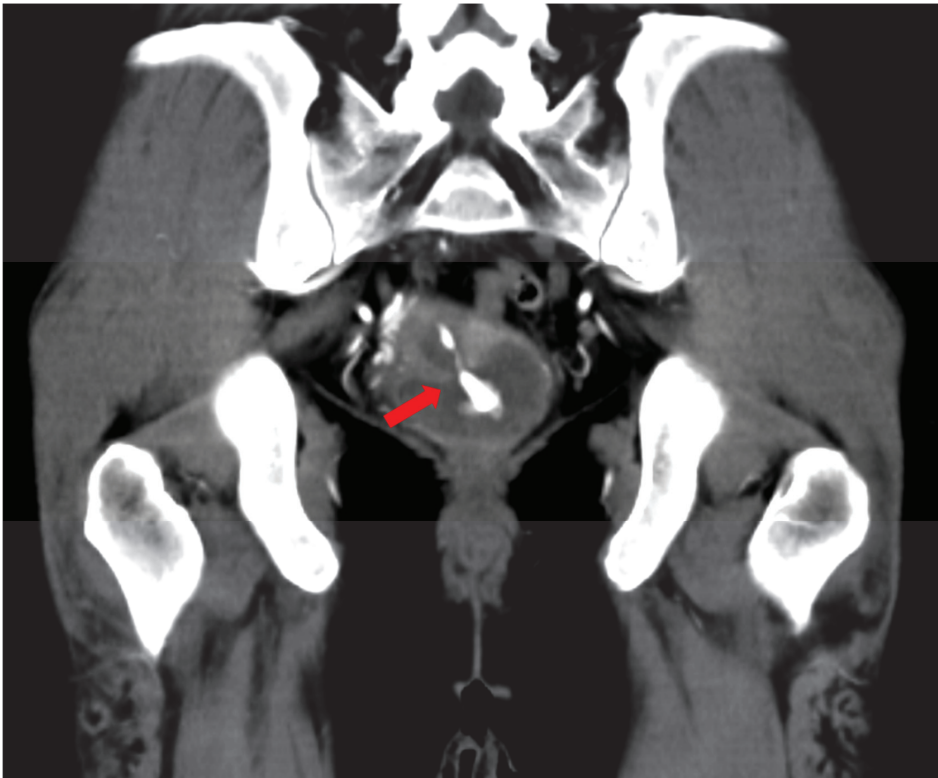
A case of a 40-year-old woman with massive vaginal bleeding. She underwent transvaginal US-directed follicle aspiration for oocyte retrieval 6 h earlier. Contrast-enhanced computed tomography (CT) on admission reveals active bleeding from the uterine ostium (arrow).
